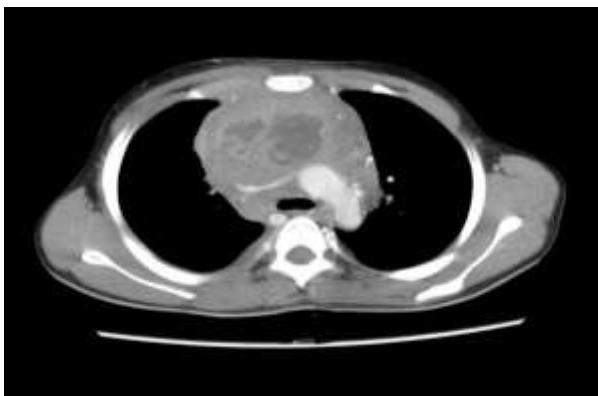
Axial CT of thorax in an 11 years old male showing thymic carcinoma.
